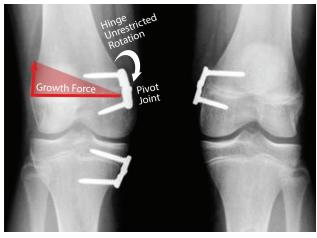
AP x-ray showing the Hinge Plate.*
